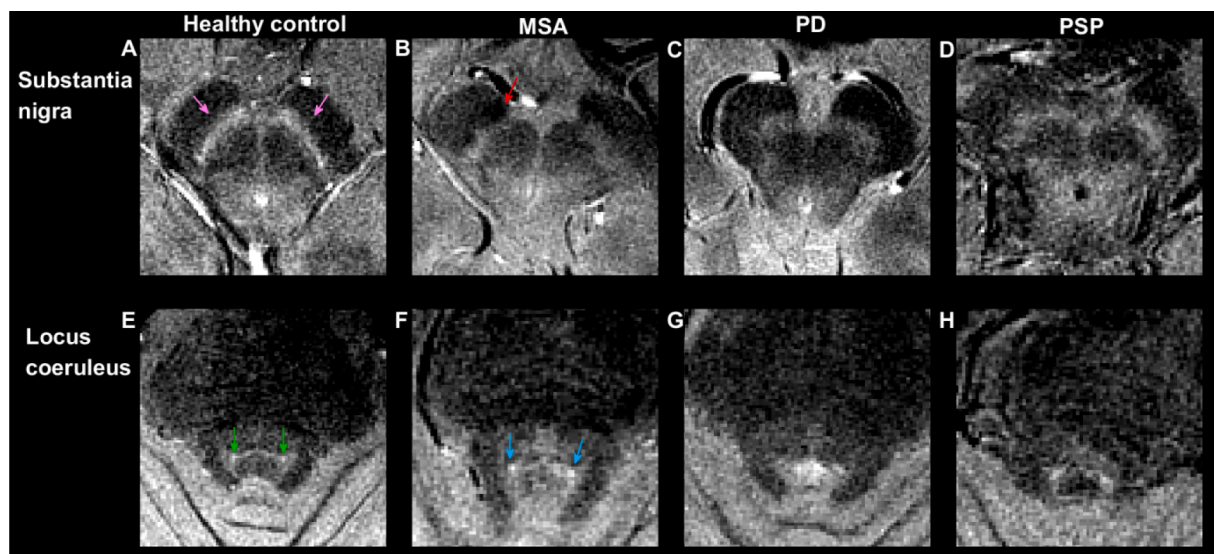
Neuromelanin-MRI results from a healthy control, an MSA, PD and PSP patient. Neuromelanin appears hyperintense. Top row (a-d) shows a slice at the level of the substantia nigra for a healthy subject with neuromelanin mostly in the substantia nigra pars compacta (pink arrows) and NM area reduction of all patients (b-d). The MSA patient (b) has a hypointense region in the region of the substantia nigra pars reticulata (red arrow), which could be due to a high amount of iron in that region as visible in Fig. 5b. The bottom row (e-h) shows axial slices at a level where the LC seems best visible in the healthy subject (green arrows), but reduced in all patients, except the MSA patient (light-blue arrows). The small size of the LC and the low SNR and CNR associated with imaging it makes the hyperintense signal from the LC region an unreliable marker for differential diagnosis. (For interpretation of the references to colour in this figure legend, the reader is referred to the web version of this article.)
